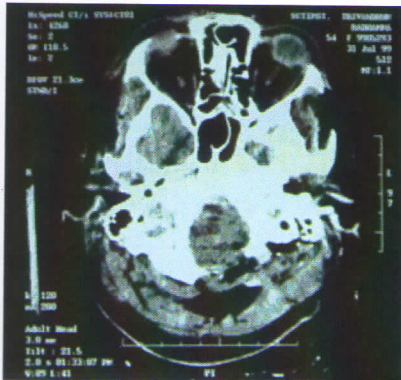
c : Post op CT scan after left posterolateral retrocondylar approach showing no residual lesion
